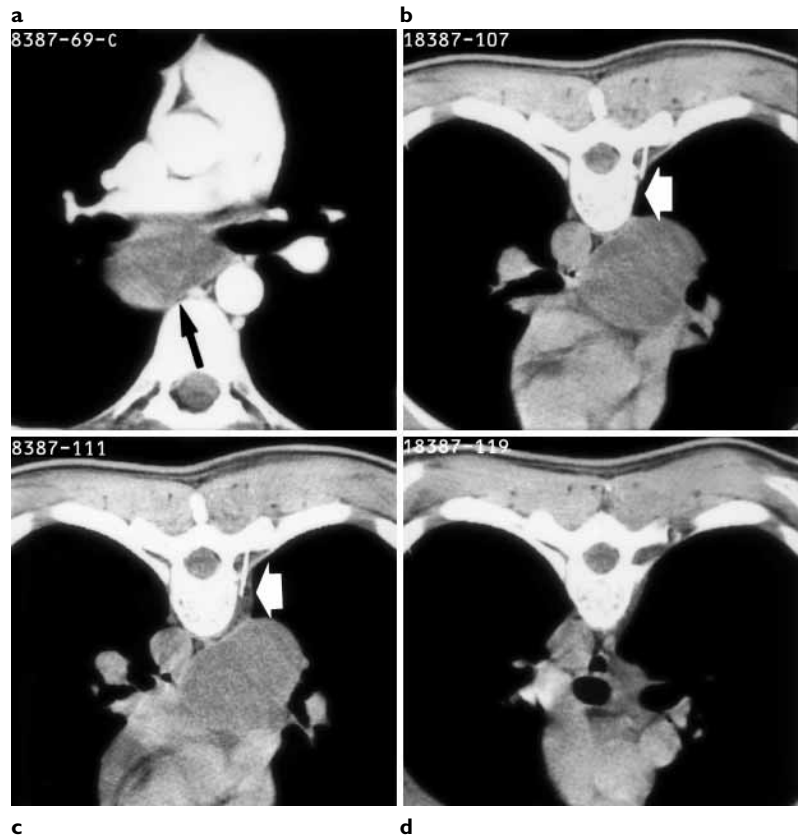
Widening of the extrapleural space for safe PTNB of mediastinal lesion. a Contrast-enhanced CT demonstrates a subcarinal mass highly suggestive of a bronchogenic cyst (arrow). b CT-guided PTNB performed in the prone position. Absence of extrapleural fat planes prevents safe mediastinal access (large arrow). c Widening of the extrapleural space is obtained by injection of 20 ml of saline while advancing the tip of the needle towards the lesion (large arrow). d Complete aspiration confirmed the diagnosis of bronchogenic cyst.
